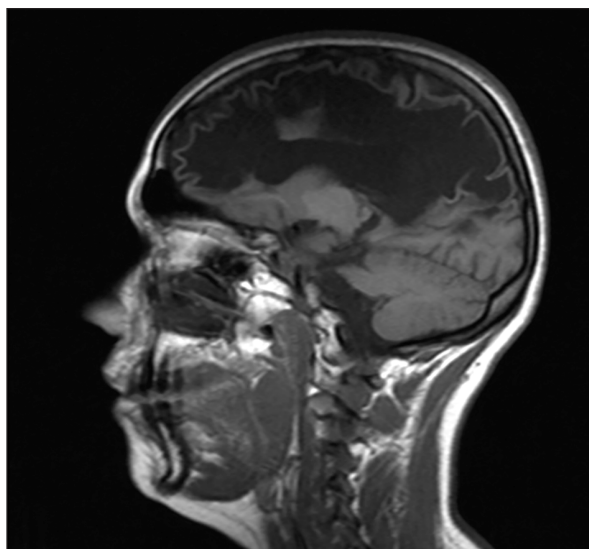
Cerebral MRI – large isointense T1-weighted area located fronto-parieto-occipital with ill-defined margins
